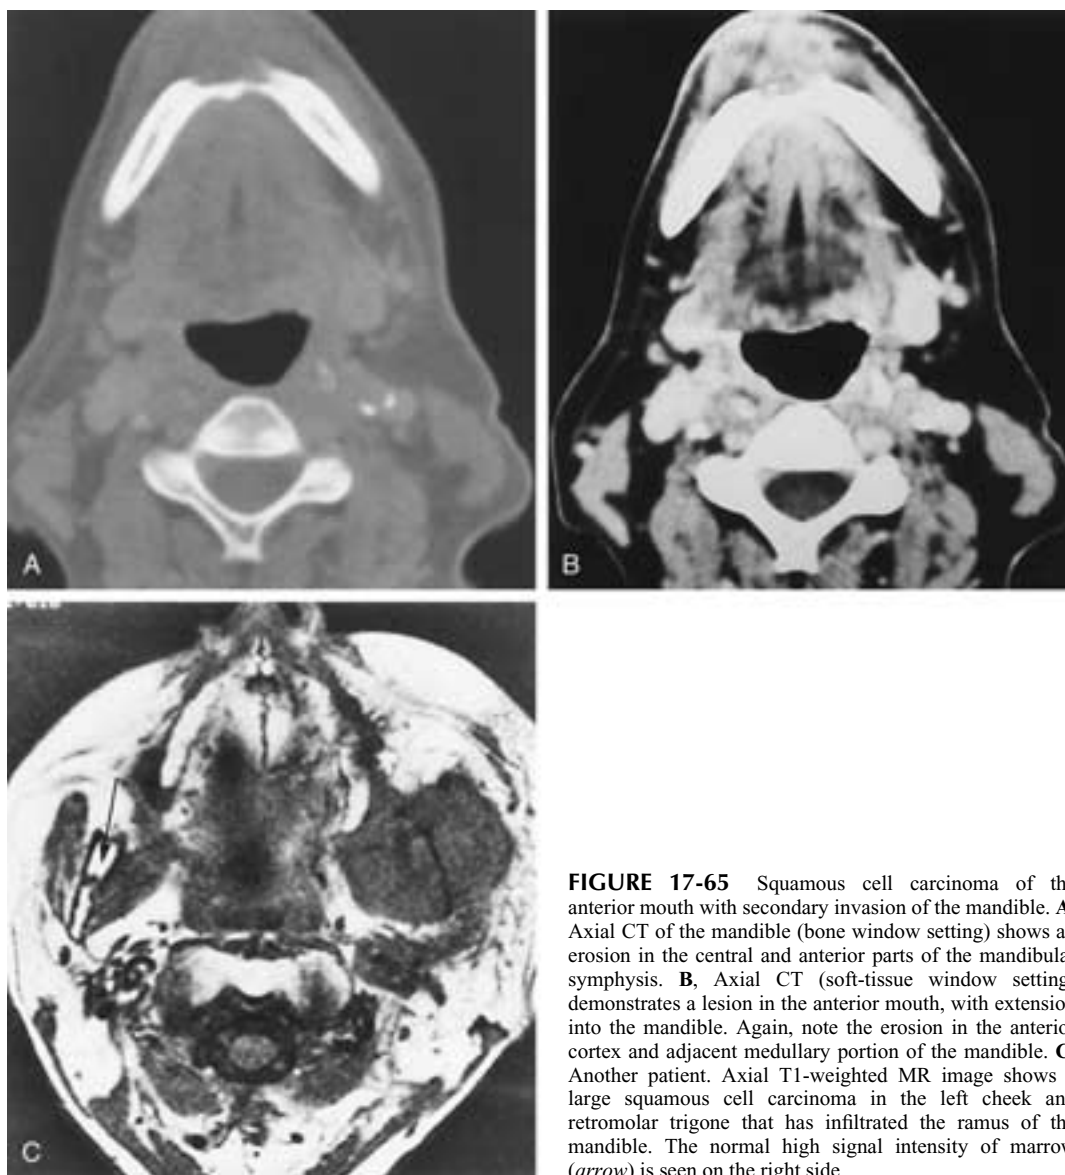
Squamous cell carcinoma of the anterior mouth with secondary invasion of the mandible. A, Axial CT of the mandible (bone window setting) shows an erosion in the central and anterior parts of the mandibular symphysis. B, Axial CT (soft-tissue window setting) demonstrates a lesion in the anterior mouth, with extension into the mandible. Again, note the erosion in the anterior cortex and adjacent medullary portion of the mandible. C, Another patient. Axial T1-weighted MR image shows a large squamous cell carcinoma in the left cheek and retromolar trigone that has infiltrated the ramus of the mandible. The normal high signal intensity of marrow (arrow) is seen on the right side.
